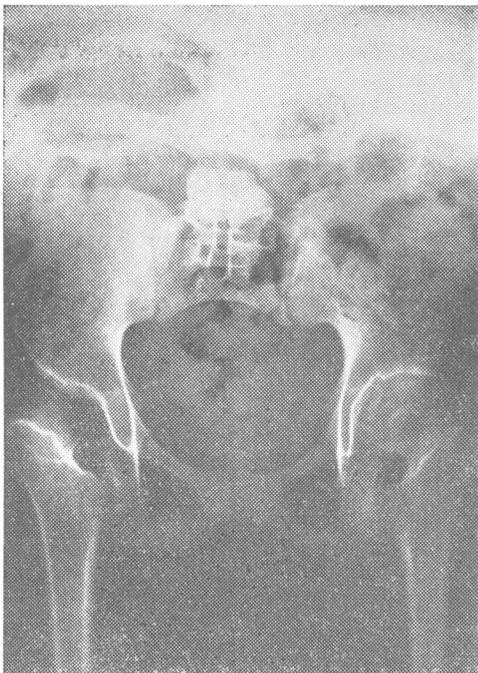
Radiograph showing absence of lumbar spine.
